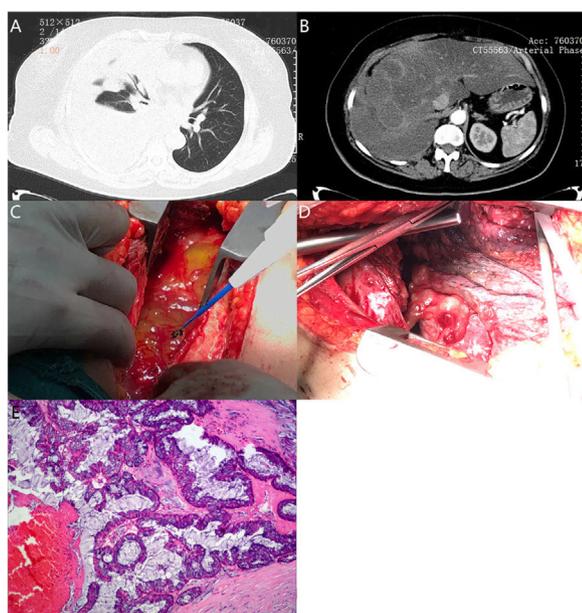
Chest CT scan showed massive pleural effusions on the right side with local atelectasis of the right lung (A). Abdominal CT scan revealed multiple low-density shadows of unequal size in the liver, and the edge of the lesions were slightly enhanced (B). An open thoracotomy revealed 1500 ml free mucus in the right pleural space (C), and multiple masses along the pleura, diaphragm and liver (D). Postoperative pathological showed low-grade mucinous neoplasm (E).
